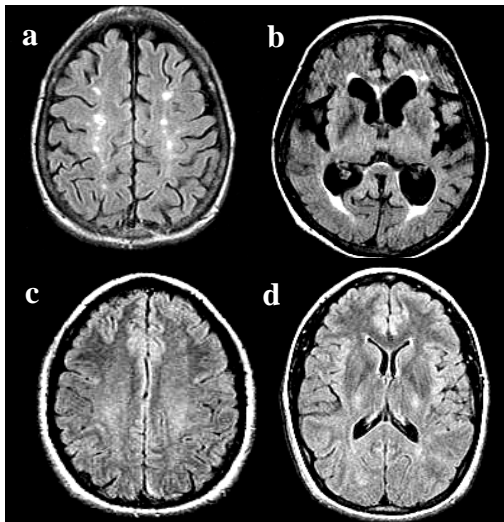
FLAIR images of an SLE patient with abnormal high signal intensity in the area of subcortical white matter (a), periventricular white matter (b) and an SLE patient with negative MRI (c, d).
